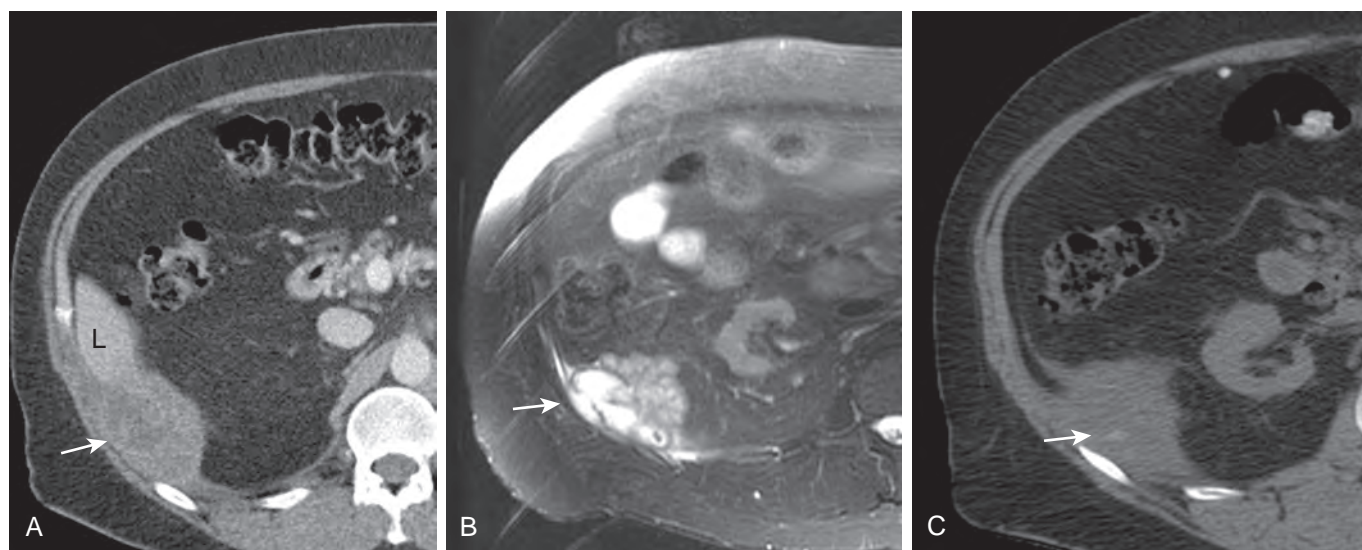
Spilled gallstones resulting in a large perihepatic abscess. Patient presented 9 months after LC with low-grade fever, fatigue, and lack of appetite. Contrast-enhanced CT (A) and axial T2-weighted MR (B) demonstrate a multiseptate abscess (*arrow*) caudal to right lobe of liver (L). The small calcified spilled gallstone within it, the nidus of the abscess, is seen only on noncontrast CT (C, *arrow*).
